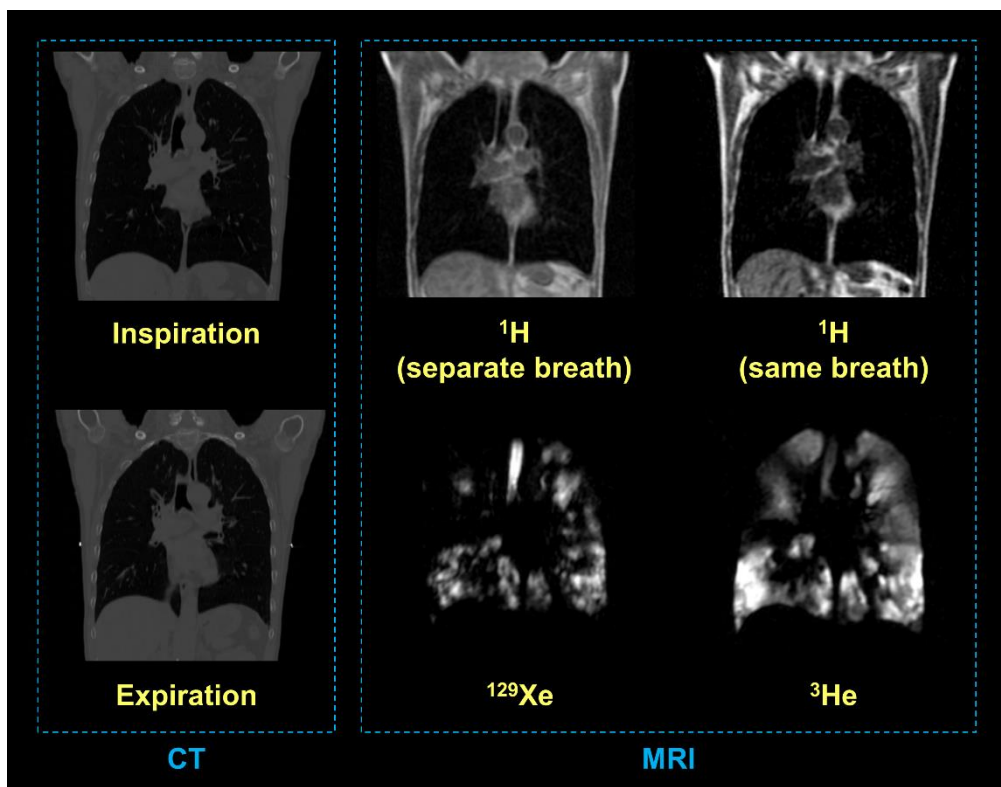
Example coronal slices of CT (left) and MR (right) images acquired. Inspiratory CT was acquired at the same inflation state of FRC+1L as for all MR images. Separate and same breath anatomical ^1H MRI were acquired for ^{129}Xe and ^3He , respectively.
